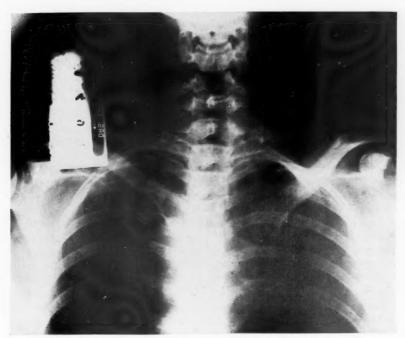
Case 2: Roentgenogram showing the result of the removal of most of the right cervical rib.
